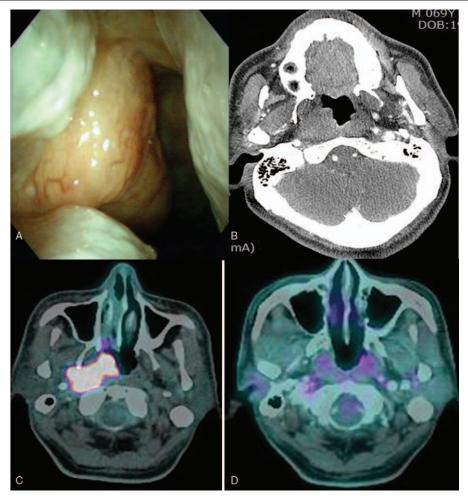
With lymphoma on the torus tubalis of the nasopharynx, the nasal endoscopy revealed a right hypertrophied mass on torus tubalis (A). The neck computed tomography image showed a homogenous mass on the nasopharynx (B). Positron emission tomography scanning showed enhanced mass which revealed a 3.8 × 2.4 cm sized hypermetabolic mass (C). No mass on the nasopharynx after chemotherapy for lymphoma.
